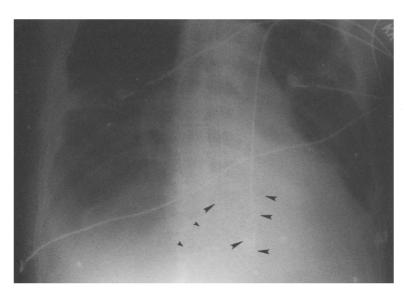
Chest x-ray film after migration. *Large arrows* show filter prongs spread open in tricuspid valve area. *Small arrows* show that first filter has not moved.
